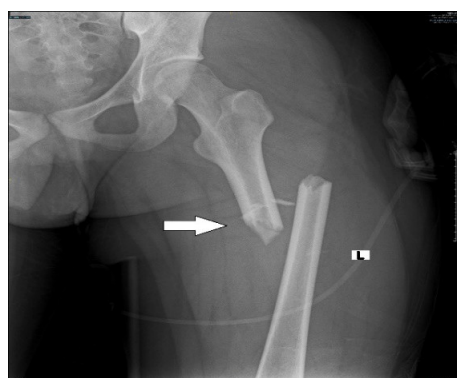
X-ray of the femur at the time of admission: Fracture of the upper third of the left femur
